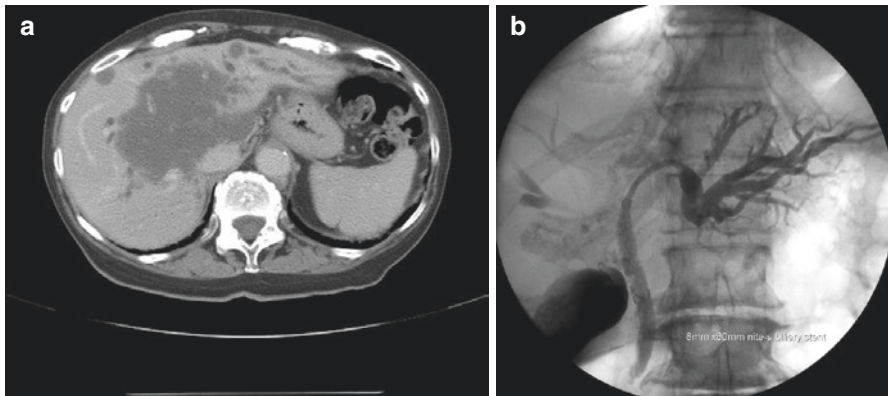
(a) CT image of intrahepatic cholangiocarcinoma presenting as a major mass in a patient with weight loss and jaundice. (b) Palliation with placement of single self-expanding metal stent into the dominant left intrahepatic duct. NITI-S SEMS (TaeWoong Inc., Seoul, Korea). Reprinted from *Clinical Gastroenterology and Hepatology*, 7, Kozarek RA, Inflammation and Carcinogenesis of the Biliary Tract: Update On Endoscopic Treatment, s89–94 (2009), with permission from Elsevier
